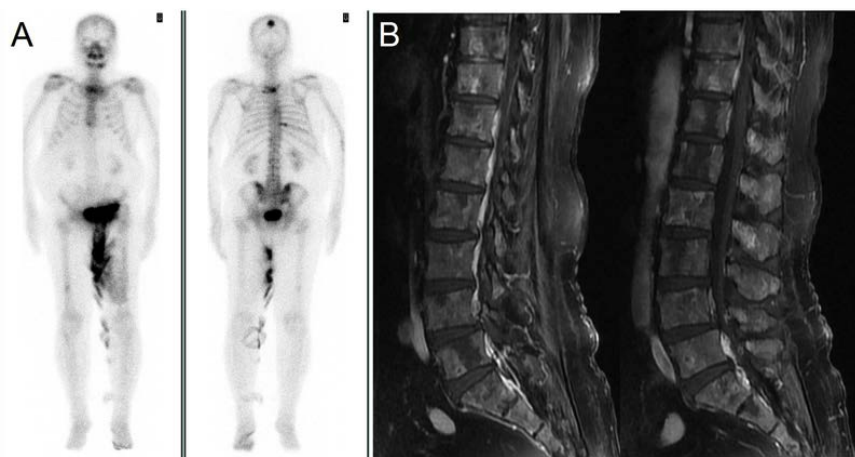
Image studies. A) Bone scan showing a few hot spots over skull, manubrium, and ribs. Also noted are the accumulation of radiotracer in bladder and the urine collecting bag. B) Magnetic resonance imaging revealing diffuse destructive lesions in bone marrow of lower thoracic, lumbar spine and sacrum (T1 fat saturated post-contrast).
